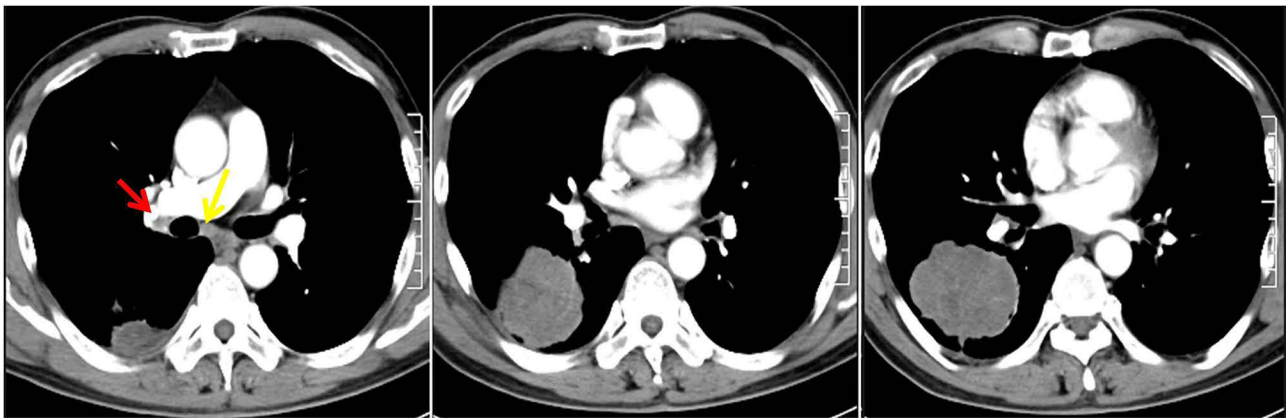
Contrast-enhanced computed tomography of the patient on admission. Red arrow: right hilar lymph node. Yellow arrow: mediastinal lymph nodes.
